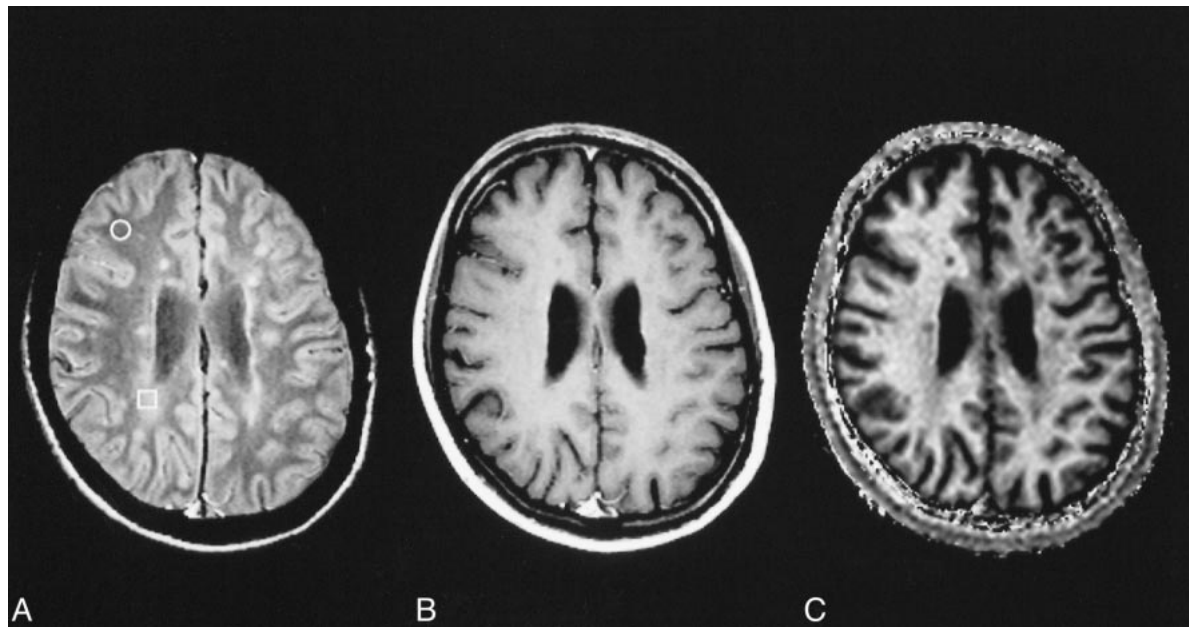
NAWM (circle) and "dirty white matter" (square) in MS on spin-echo proton density-weighted (2060/20/1) image (A). No corresponding changes are seen on the postcontrast T1-weighted (510/14/2) image (B). In the calculated image showing the transfer rate k_{for} , the area of dirty white matter is clearly visible (C).
